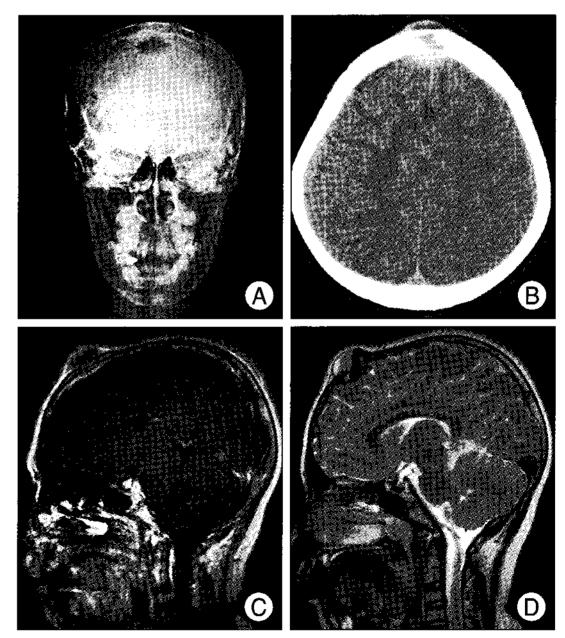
Skull x-ray (A) showing a 2.5 x 2.0 cm-sized lytic bony defect in the mid-frontal region. Computed tomography (B) showing an epidural hematoma with acute and subacute components. Sagittal enhanced magnetic resonance imaging (MRI) (C) showing an epidural hematoma. Sagittal T2-weighted MRI (D) showing mixed cystic fluid with intracystic hemorrhage.
